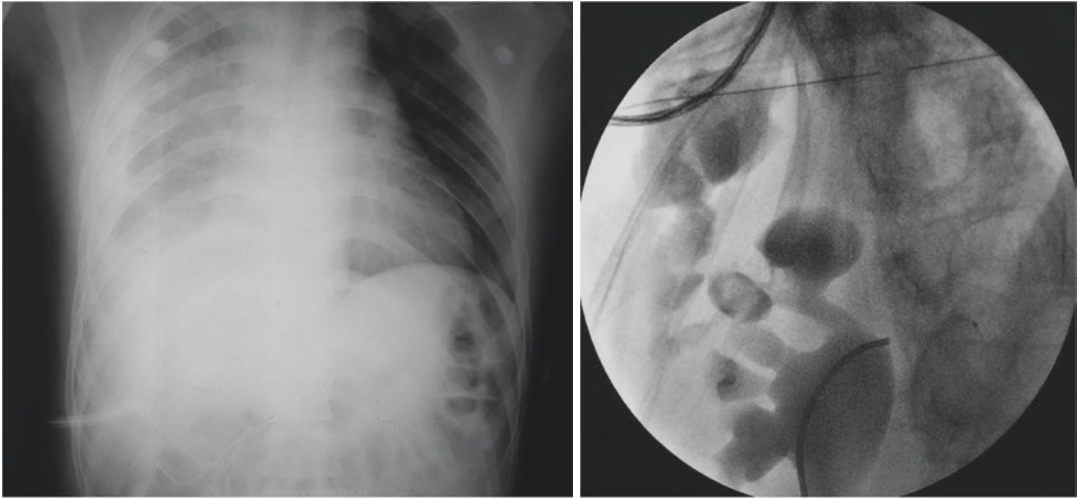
Chest X-ray, right hydropneumothorax, nephropleural fistula from the upper calyx from a supracostal tract
